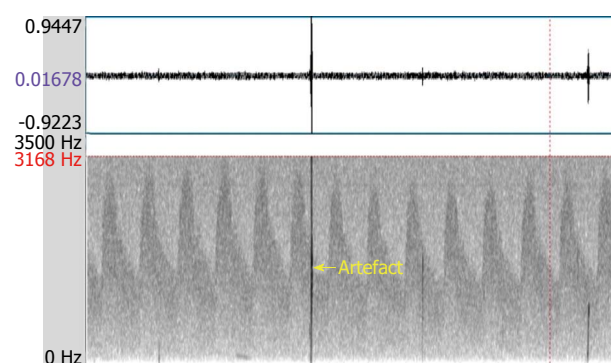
Artefact. The NICOLET Pioneer transcranial Doppler 4040 Doppler Waveform Analyzer was used.
